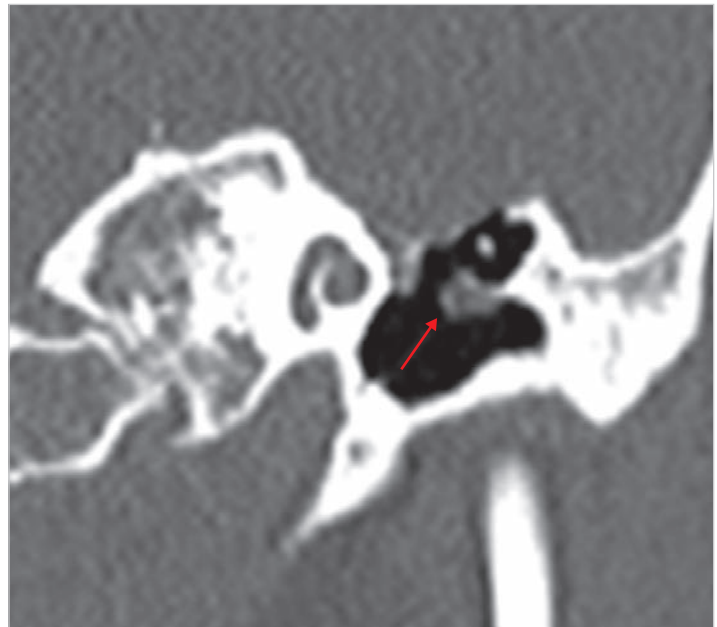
CT scan of the same case, coronal view. A small epitympanic cholesteatoma is visible (arrow).
